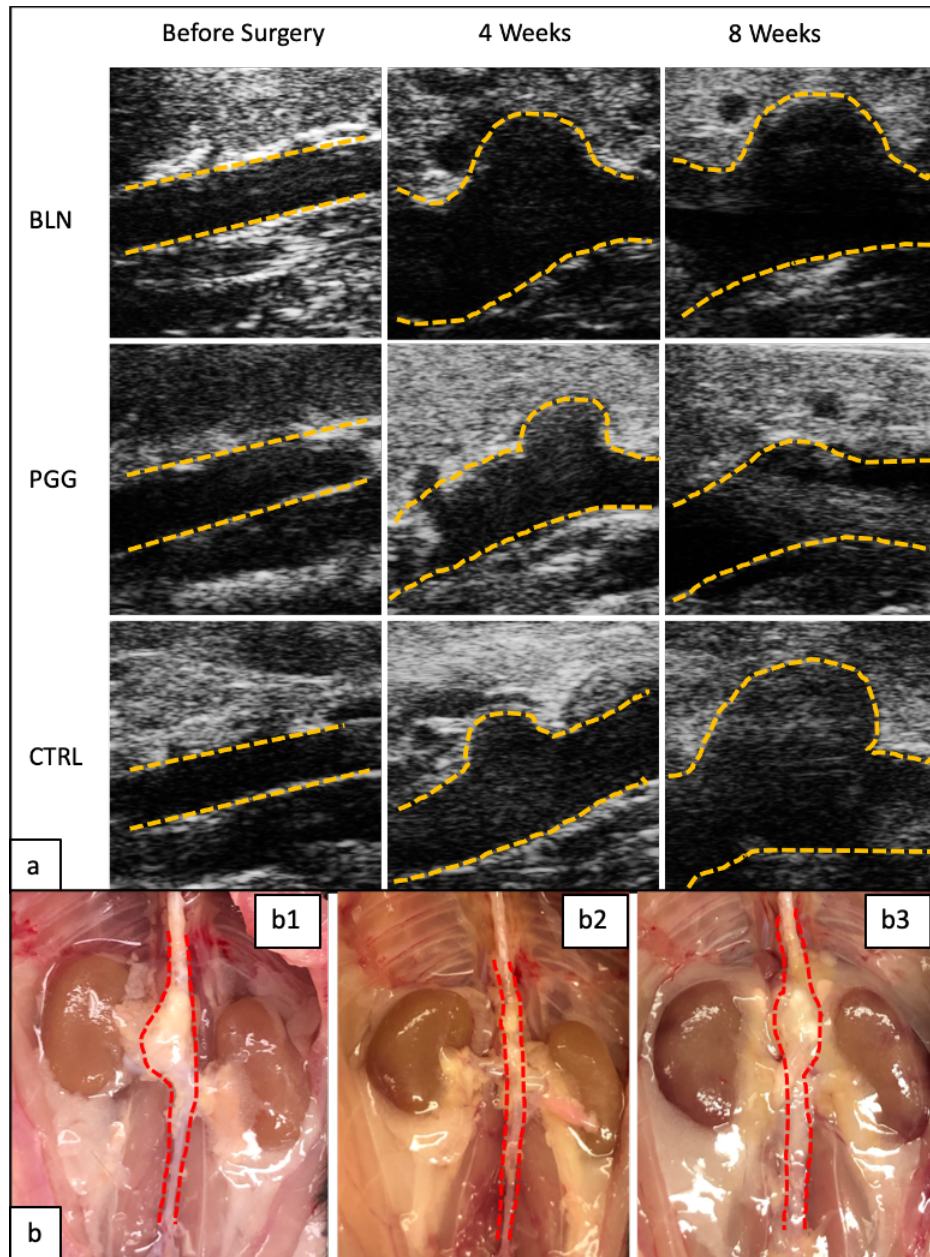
In-vivo* ultrasound and percentage of dilation change in all three groups. a. Representative B-mode *in-vivo* ultrasound images of abdominal aortas before pump implantation, at 4 weeks when the infusion of the Ang II was finished, and 8 weeks when the treatment was finished; b. Gross view of the aortas from BLN-NPs (b1), PGG-NPs (b2), and control group (b3) at the endpoint.
